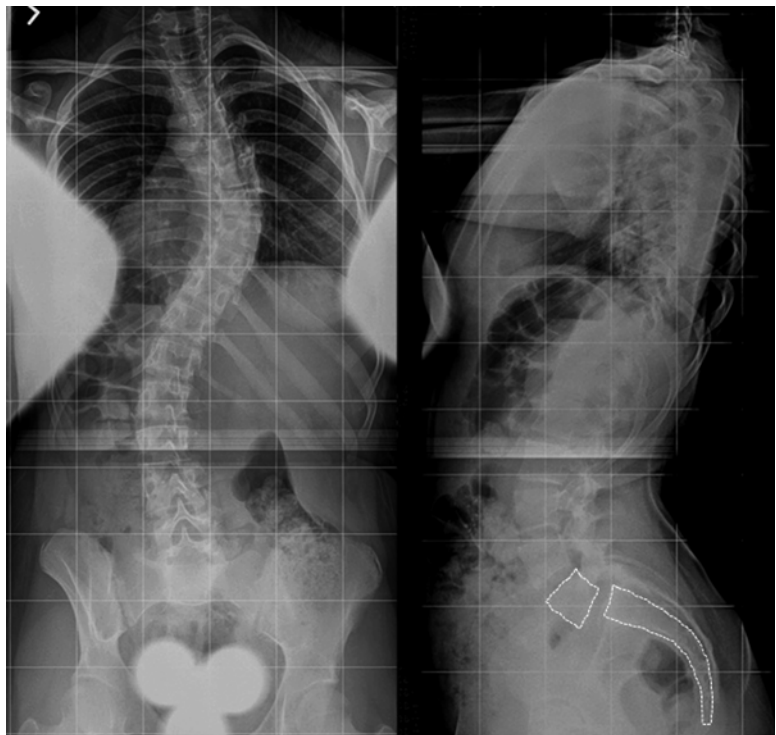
AP and lateral radiograph showing a grade 3 L5–S1 spondylolisthesis and a 25° olisthetic scoliosis
